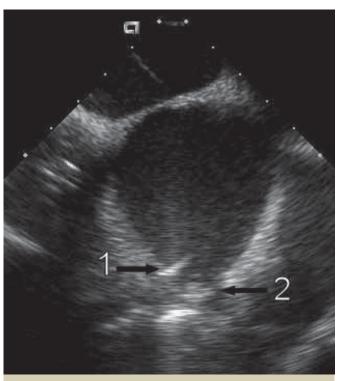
An intracardiac echocardiographic image of the left atrium taken from the right atrium using a longitudinal phased array catheter (AcuNav catheter, Siemens). Arrow 1 is pointing at a catheter which is a little deep within the left inferior pulmonary vein. Arrow 2 is pointing at the proximal portion of the left superior pulmonary vein.
